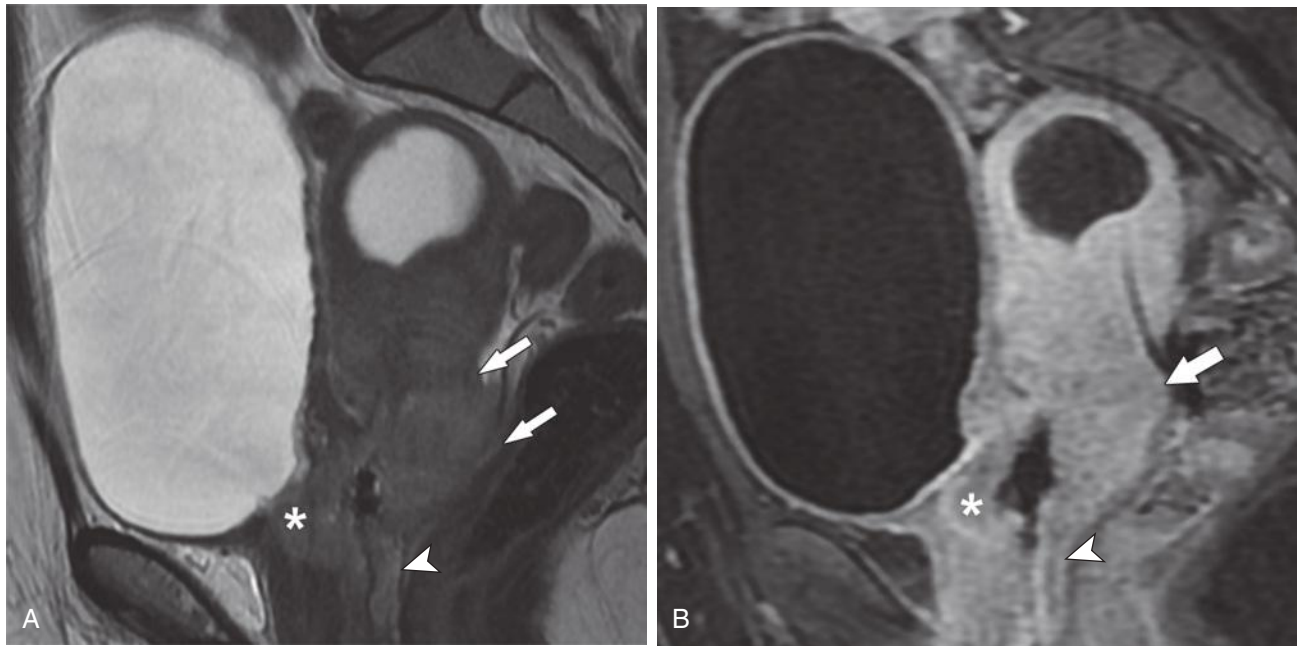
Stage IV cervical cancer. Sagittal T2-weighted image (A) and gadolinium-enhanced fat-saturated T1-weighted image (B) show a large cervical mass extending into the lower uterine segment (arrows) and vagina (arrowhead). The mass also involves the bladder neck (asterisk). Note the distended urinary bladder related to bladder outlet obstruction.
